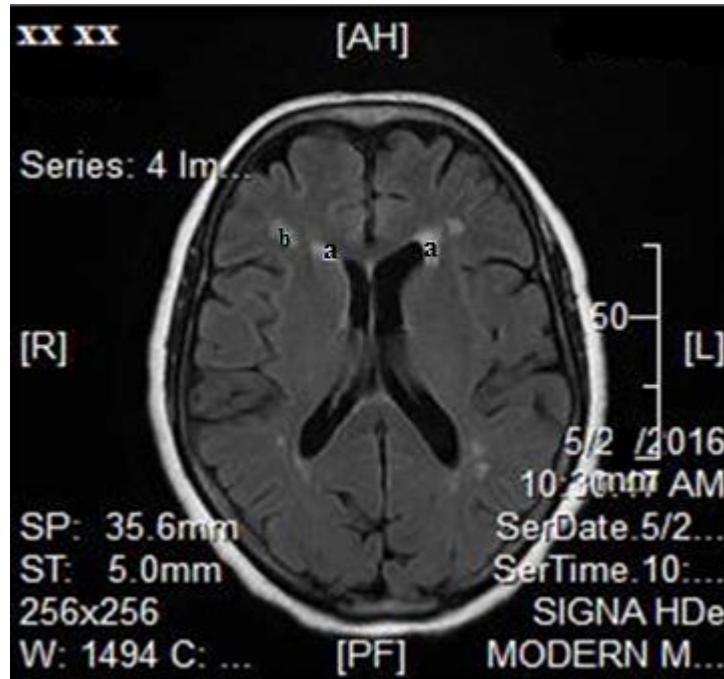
(B.2) shows an axial, FLAIR MR image for fifty years old uncontrolled hypertensive female, with duration less than five years; she had grade two periventricular (a) and grade two deep (b) WMLs.
